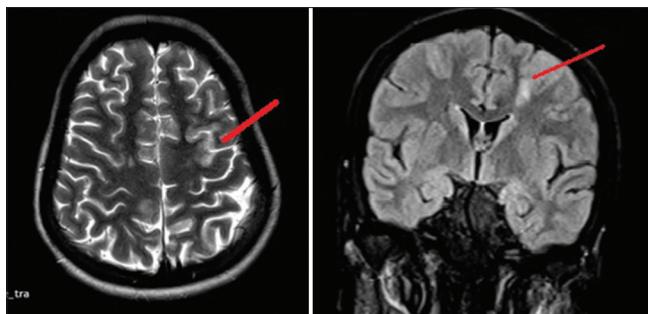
There is T2, FLAIR hyperintensity in left frontoparietal cortex
